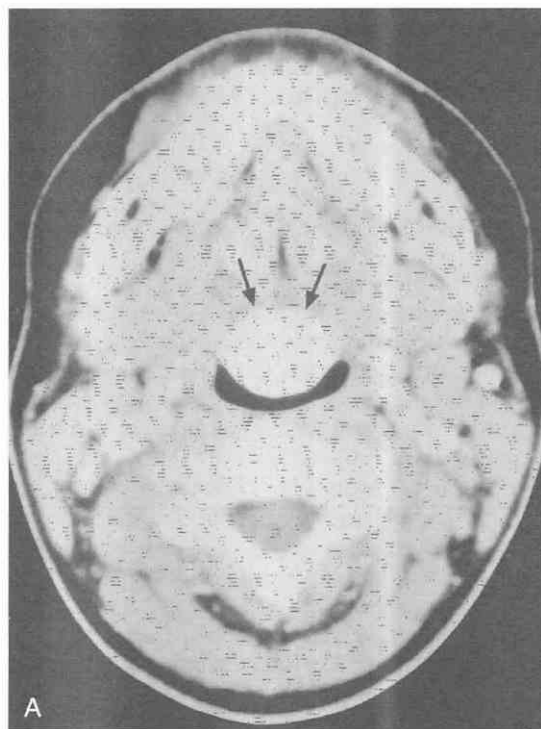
A, Enhanced CT image at the level of the oropharynx shows a well-circumscribed, homogeneously enhancing mass (*arrows*) in the tongue base, consistent with a diagnosis of ectopic lingual thyroid tissue. B, CT scan in the same patient at the expected level of the thyroid gland demonstrates no paratracheal thyroid tissue (*arrowheads*).
